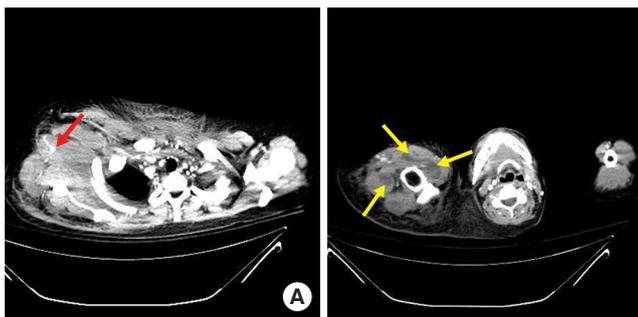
Computed tomography angiography of upper extremity and chest wall. (A) Active bleeding with large amount of hematoma from the suspicious right lateral thoracic artery (red arrow). (B) Diffuse intramuscular and intermuscular hematoma (yellow arrows) in the right upper extremity which indicated compartment syndrome with muscle necrosis.
